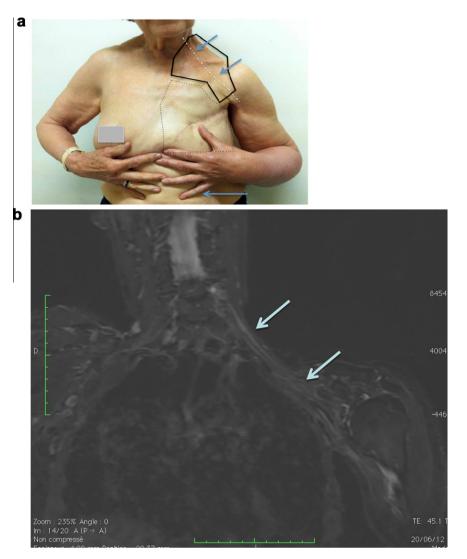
Radiation-induced brachial plexopathy (RIBP): (2a) a 74-year-old woman with left breast cancer 41 years ago was treated by breast (RT field black dotted line) and axillary-supraclavicular (RT field black full line) irradiation followed by mastectomy: she developed arm lymphoedema, supraclavicular fibrosis and RIBP (plexus along the white dotted line) showing progressive sensory and motor upper limb signs for 4 years. (2b) Corresponding MRI in frontal view with supraclavicular and axillary compressive fibrosis without cancer recurrence.
